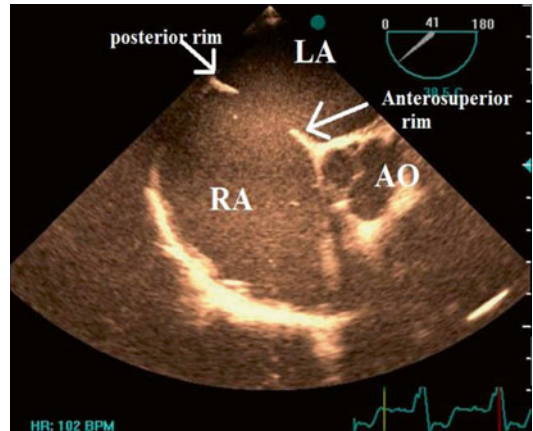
Transesophageal echocardiography in short-axis view showing aortic (anterosuperior rim) and posterior rims. *AO* aorta, *RA* right atrium, *LA* left atrium
